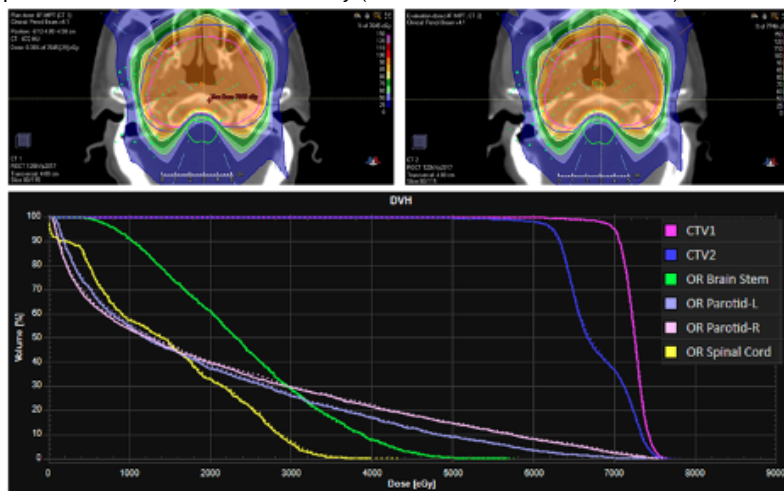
Dose matrices calculated on paired CT (PCT) (top left) and synthetic CT (SCT) (top right) as well as the dose-volume histogram (bottom) (solid line: PCT and dashed line: SCT) for a patient with average performance of dosimetry accuracy (3%/3mm gamma passing rate = 97.7%)
